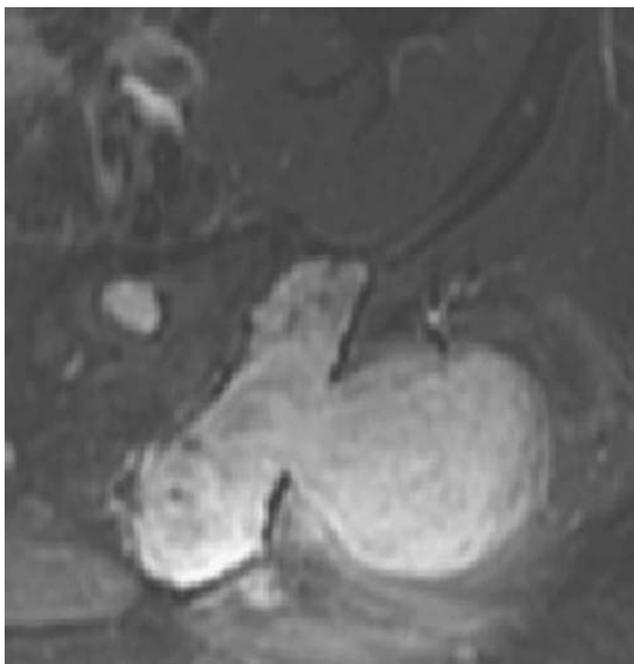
Axial T1-weighted image with fat saturation after gadolinium administration shows that the mass is enhancing and replaces the marrow in the posterior ilium. Note the sharp demarcation anteriorly. The soft tissue component also is uniformly enhancing with minimal surrounding edema and inflammation.
